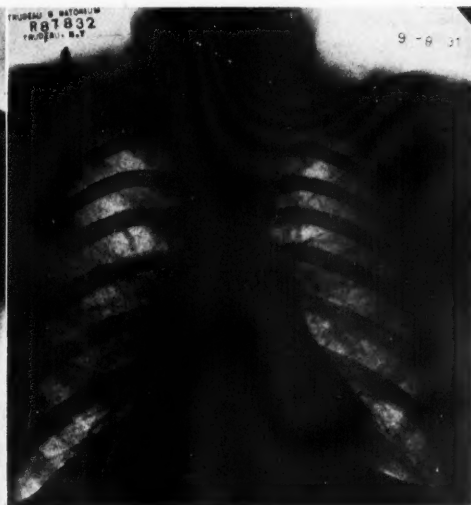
Physical examination: right lung, negative; left lung, râles throughout. X-ray findings: right lung, infiltration to clavicle; left lung, marked clearing of infiltration in the lower half.
